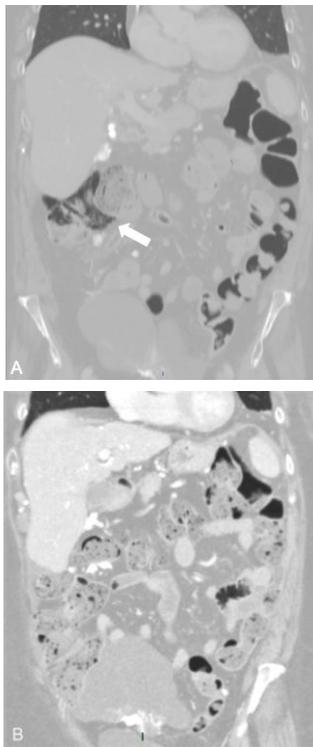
Coronal oblique multiplanar reconstruction from helical CT scan displayed in a large lung-size window. Coronal reconstruction in December 2019 (A) demonstrated a reduction in dimension and extent of the intramural colonic air collections (arrow) 6 months after the first detection of PCI, still maintaining a multilocular appearance. No intra-abdominal free gas signs were detected. A further CT scan in May 2020, a year later, showed the complete remission of pneumatosis (B).
